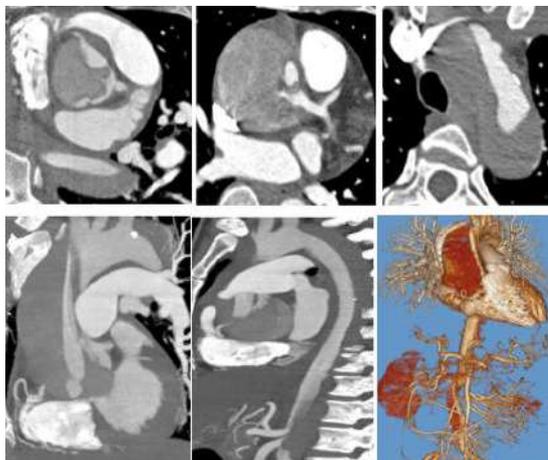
(A-F). CT Aortic angiogram showing dissection of aortic root, ascending and descending thoracic aorta(Debakey Type 1/ Stanford Type A).Normal origin of right and left coronary arteries from true lumen seen.
